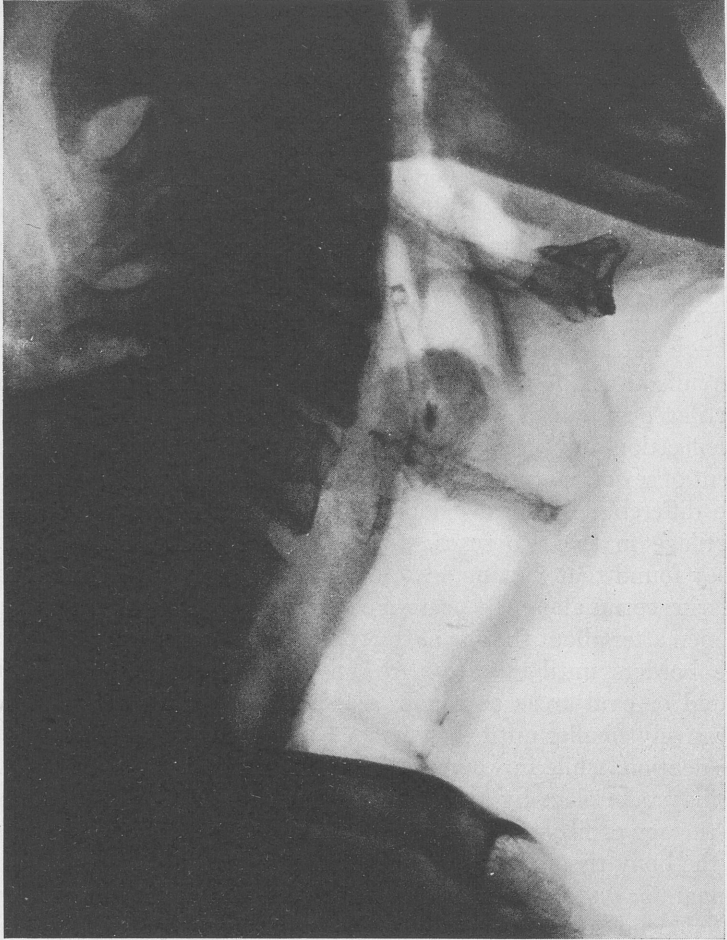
A roentgenogram of a man, aged sixty years, showing ossification of the superior cornua.
